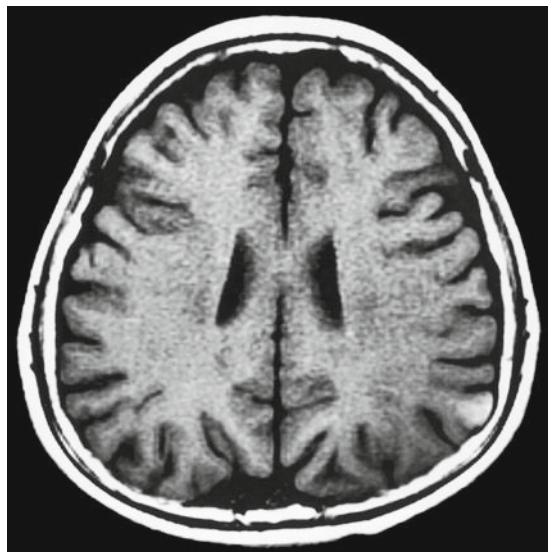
A 14-year-old boy with angiocentric glioma. Cortex and subcortical white matter in the left parietal lobe is involved. Reflecting its infiltrative nature, the lesion is seen as areas of abnormal intensity without displacement of surrounding structures. Thinning of the inner layer of adjacent cranial bone suggests slow growth of the tumor. The lesion shows high intensity on nonenhanced T1-weighted images
